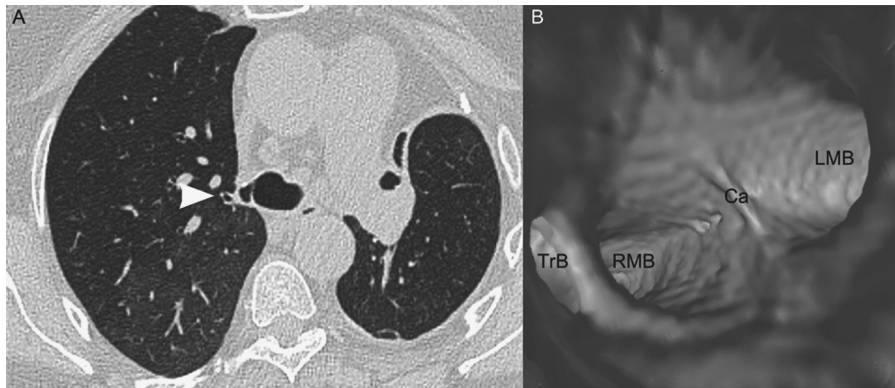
High resolution MDCT images. (A) Axial CT shows the accessory bronchus origin from right tracheal wall (arrowhead). (B) 3D volume rendering virtual endoscopic reconstruction of trachea showing right (RMB) and left main bronchi (LMB) and the ostium of the Tracheal Bronchus (TrB), arising 2 cm proximal to the carina (Ca).
